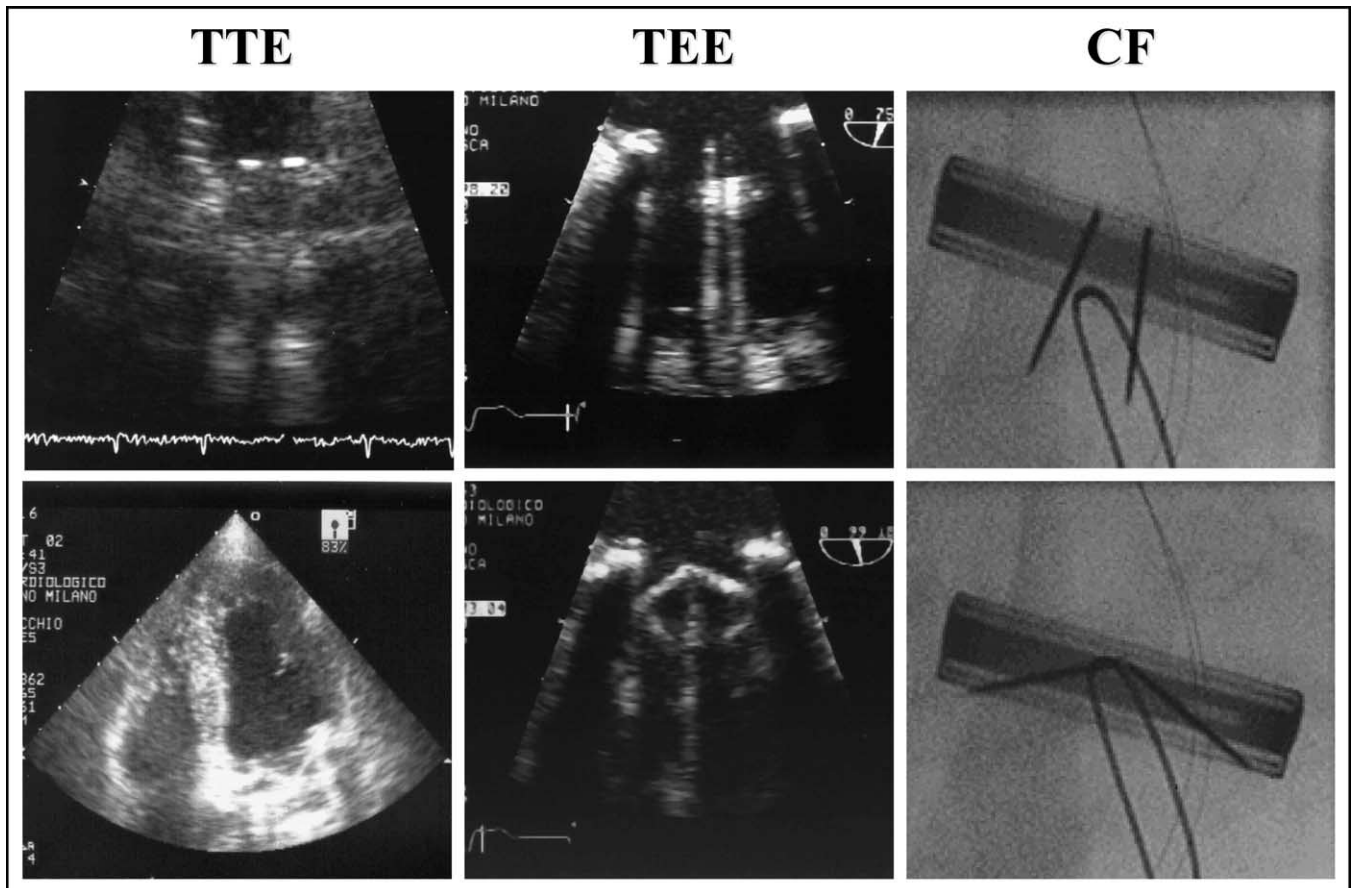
Normal functioning mitral bileaflet prosthesis: opening (*top panels*) and closing (*bottom panels*) angles in transthoracic apical 4-chamber view (*left*), TEE view (*middle*), and cinefluoroscopy (CF) (*right*).
